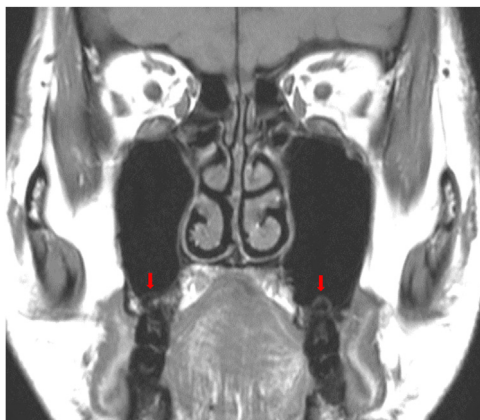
A representative T1-weighted MR image on the coronal plane demonstrating maxillary molar roots penetrating the sinus floor (arrows).
